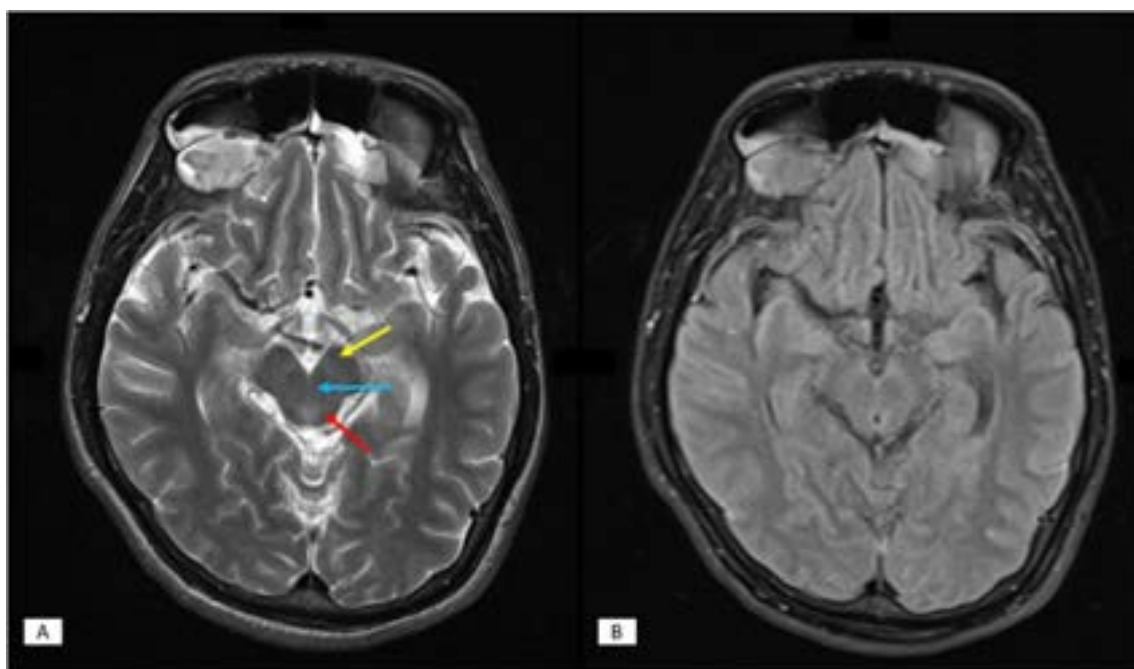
Axial MRI brain at the level of the midbrain (A) T2-weighted TSE, showing the left cerebral peduncle (yellow), the aqueduct of Sylvius (blue), and the left superior colliculus (red). (B) Corresponding FLAIR sequence. Both sequences demonstrate no abnormal signal changes in the brainstem or surrounding structures.
